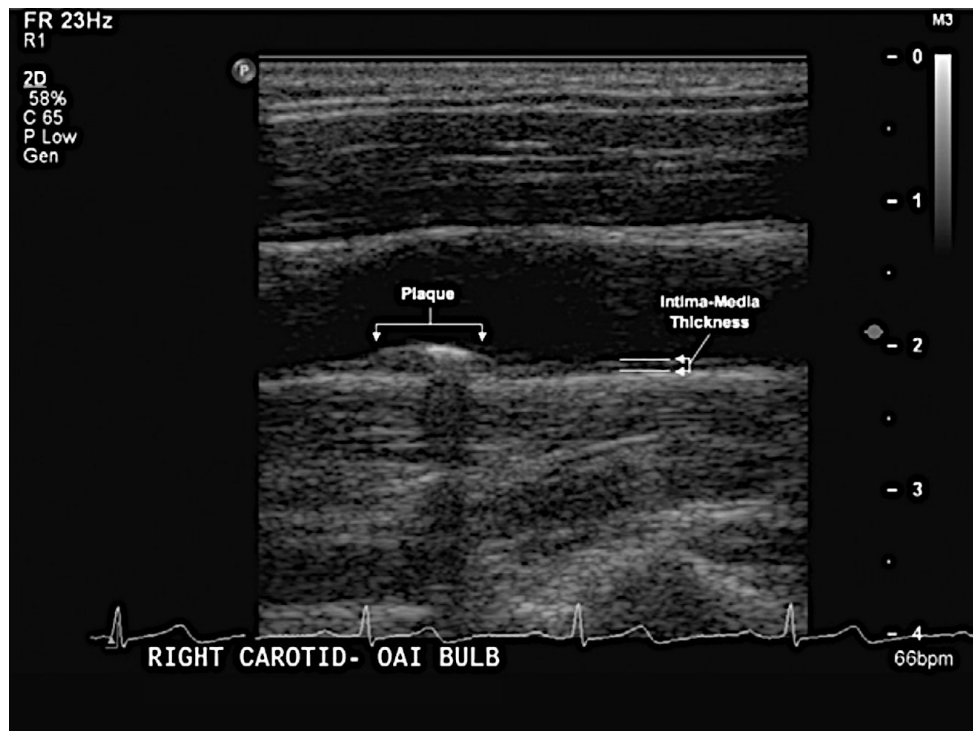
Carotid artery ultrasound image for measurement of IMT (“double line pattern”); atherosclerotic plaque present (reproduced from: (Longenecker and Hoit, 2012))
